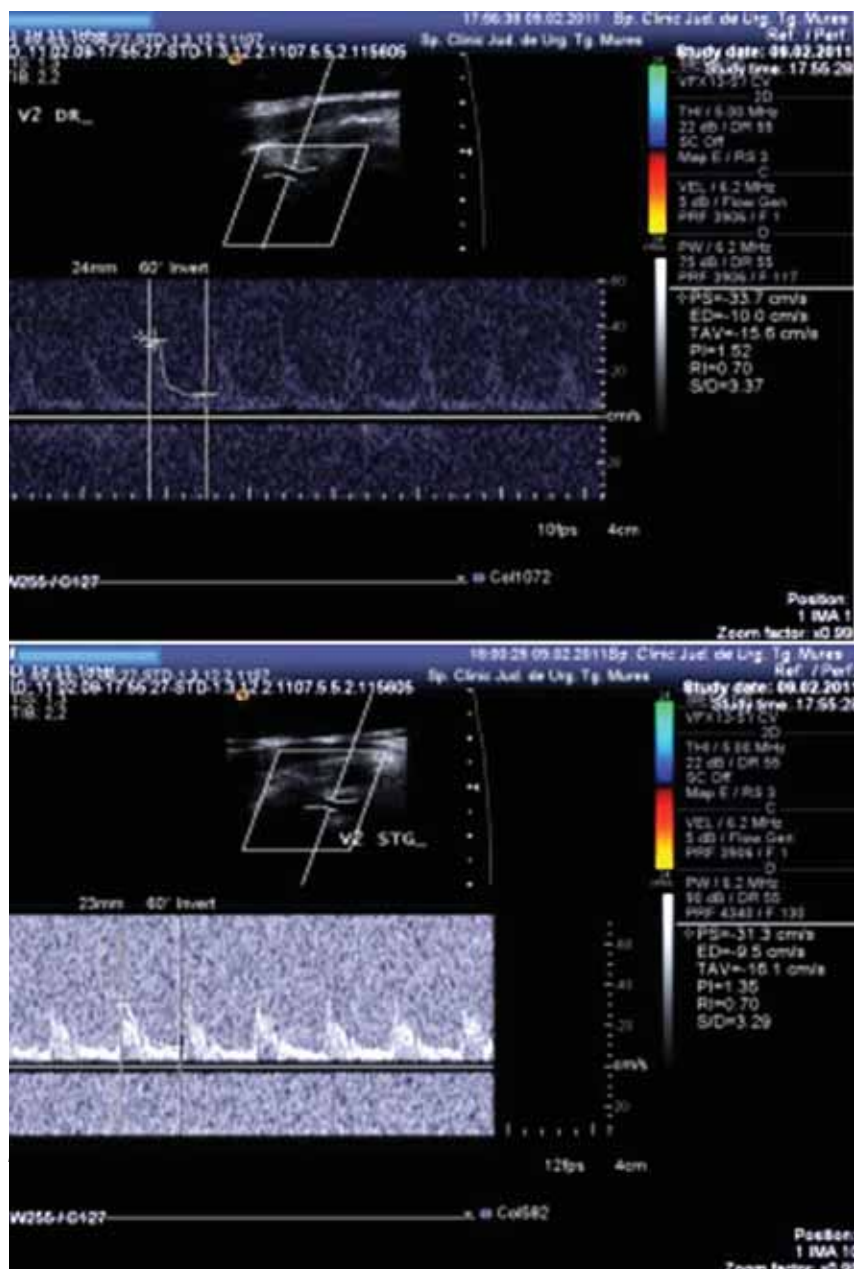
Duplex ultrasonography. V2 segment of the vertebral arteries. The blood flow is present in the vertebral arteries with slightly increased pulsatility index.
